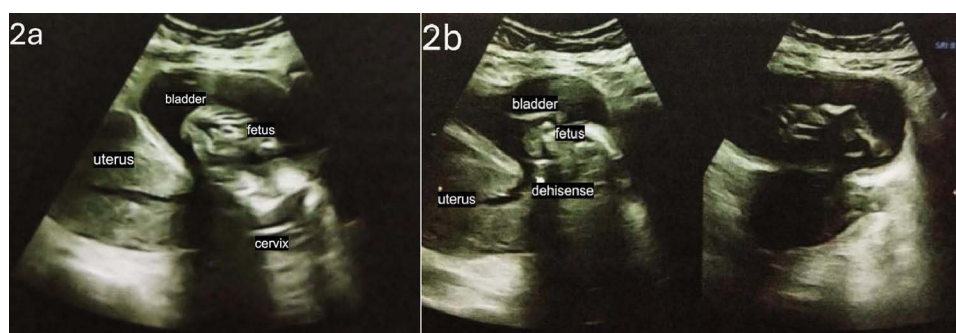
Ultrasound revealed fetus in the lumen of the vesica urinaria. (a) trigonum of the vesica urine; (b) dehiscence and the fetus.
